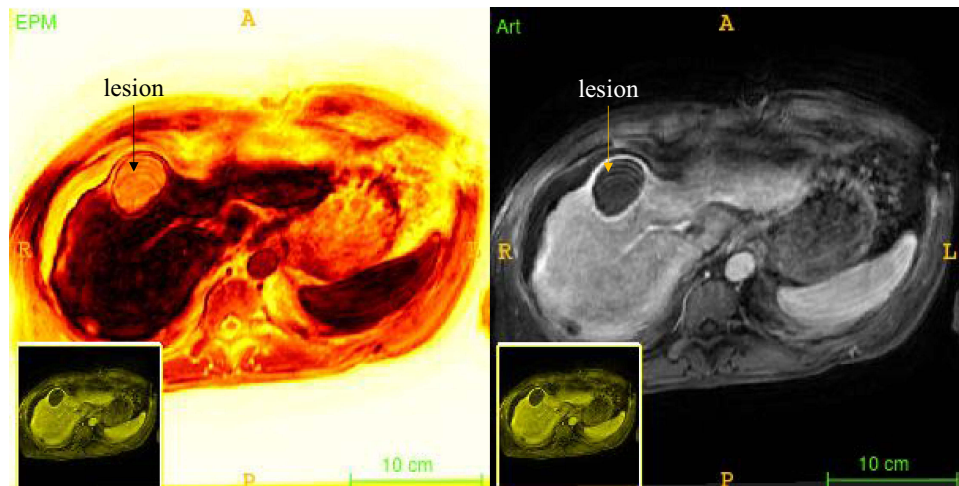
Representative ROI used for CNR analysis of the image intensity on EPM (left) and on arterial phase MRI (right) with lesion indicated.
